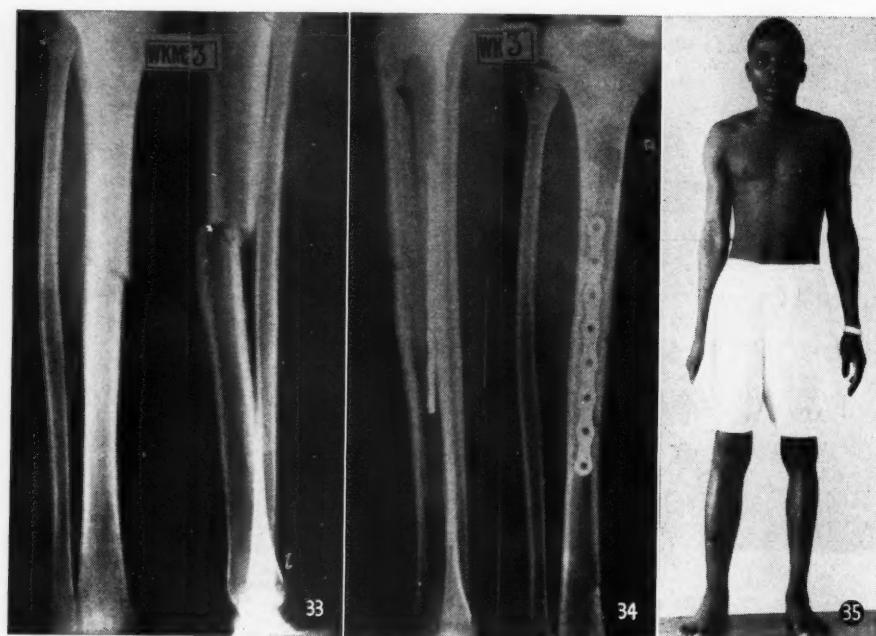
Case No. 8. Pre-operative X-ray demonstrating that union is not yet in progress.
